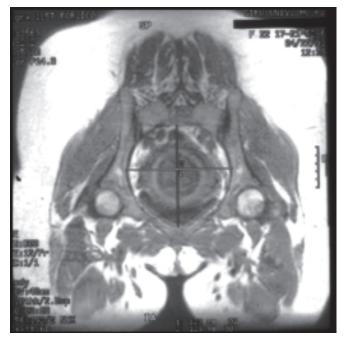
Magnetic resonance imaging pelvimetry, Martius image. The maternal pelvic shape is delineated clearly. We can obtain this image from the maternal sagittal image, which provides a theoretically better method of pelvimetry than X-ray pelvimetry
